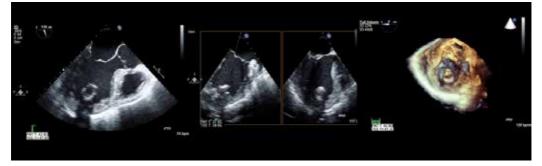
2D, simultaneous biplane and 3D transoesophageal echocardiographic images of a left ventricular cannula.
